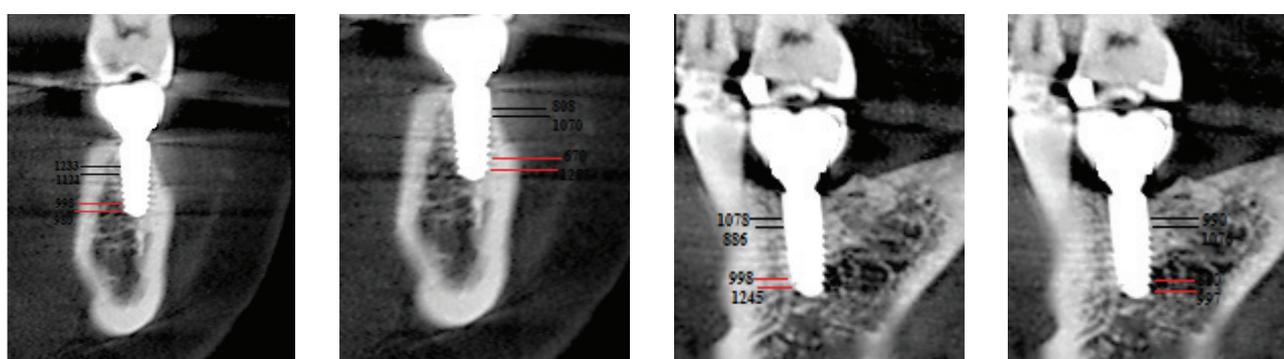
CBCT analysis of the density of bone around the first two and last two threads of implant on all the sides six months after placement (left to right mesial, distal, buccal and lingual).
